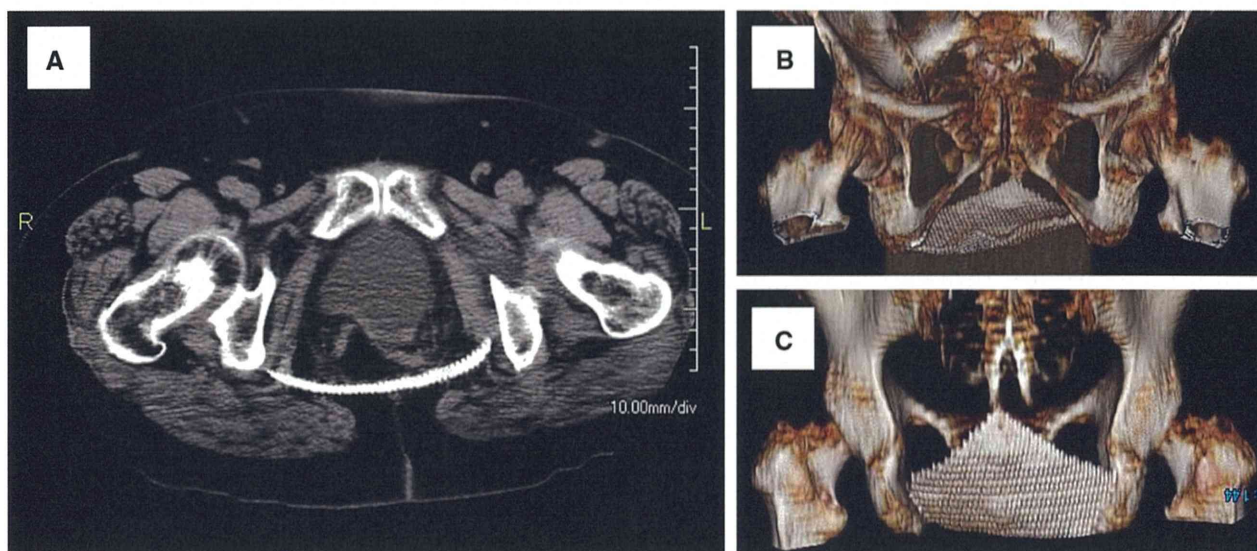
A Computed tomography (CT) scan performed in “Case 1” 2 years post-hernioplasty revealed no hernia recurrence. Reproduced from Ref. [18] with permission. B, C Three-dimensional CT images obtained 2 years postoperatively show no malposition of the titanium mesh. Anterior view (B) and posterior view (C)
